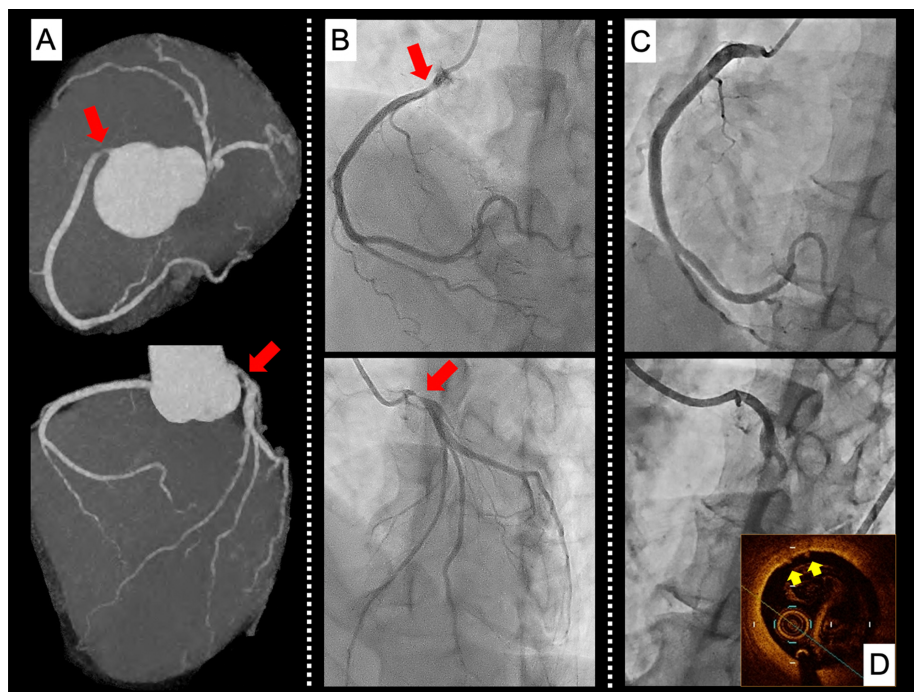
(A) Coronary computed tomography. (B) The second coronary angiography. (C) The third coronary angiography. (D) Optical coherence tomography images of the left coronary artery ostia. An emergency second coronary angiography.
